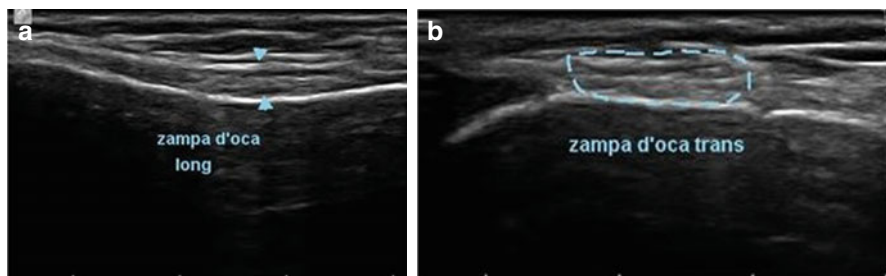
Ultrasound longitudinal examination (a) and axial examination (b) of pes anserine in normal anatomical situation
